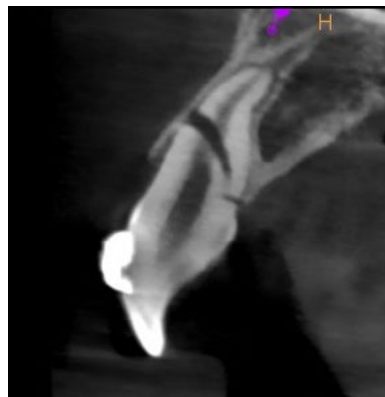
Sagittal slice of the CBCT of 11
